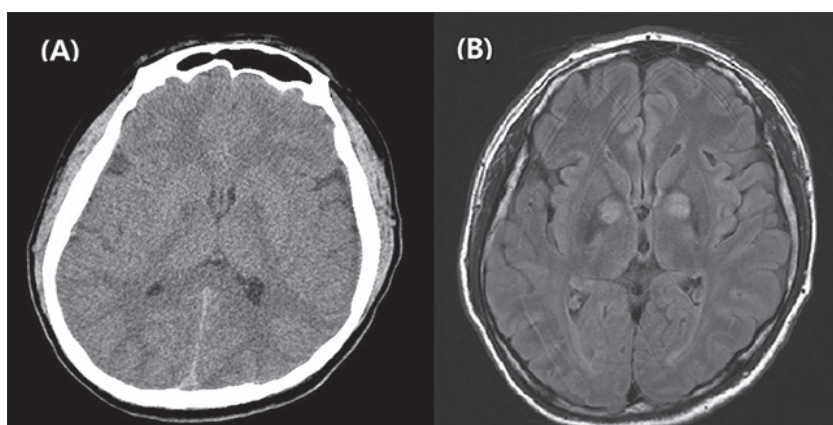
Images from (A) the brain CT upon ED admission and (B) the brain MRI on day five of hospitalization
